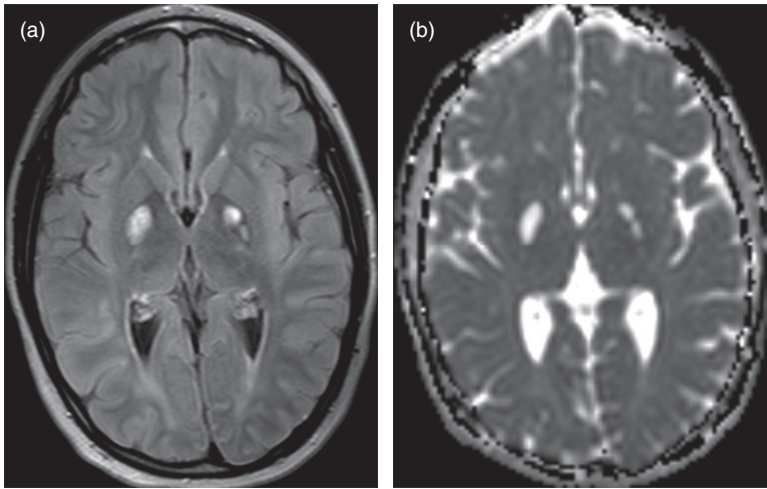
12-year-old male with methylmalonic acidemia, global developmental delay, intractable seizures, and new tremors. (a) Axial FLAIR images demonstrate signal abnormality in the basal ganglia and patchy periventricular gliosis, new findings compared to a study performed 4 years prior. (b) Axial apparent diffusion coefficient maps indicate that the signal abnormality has increased diffusivity in keeping with a subacute to chronic metabolic insult.
